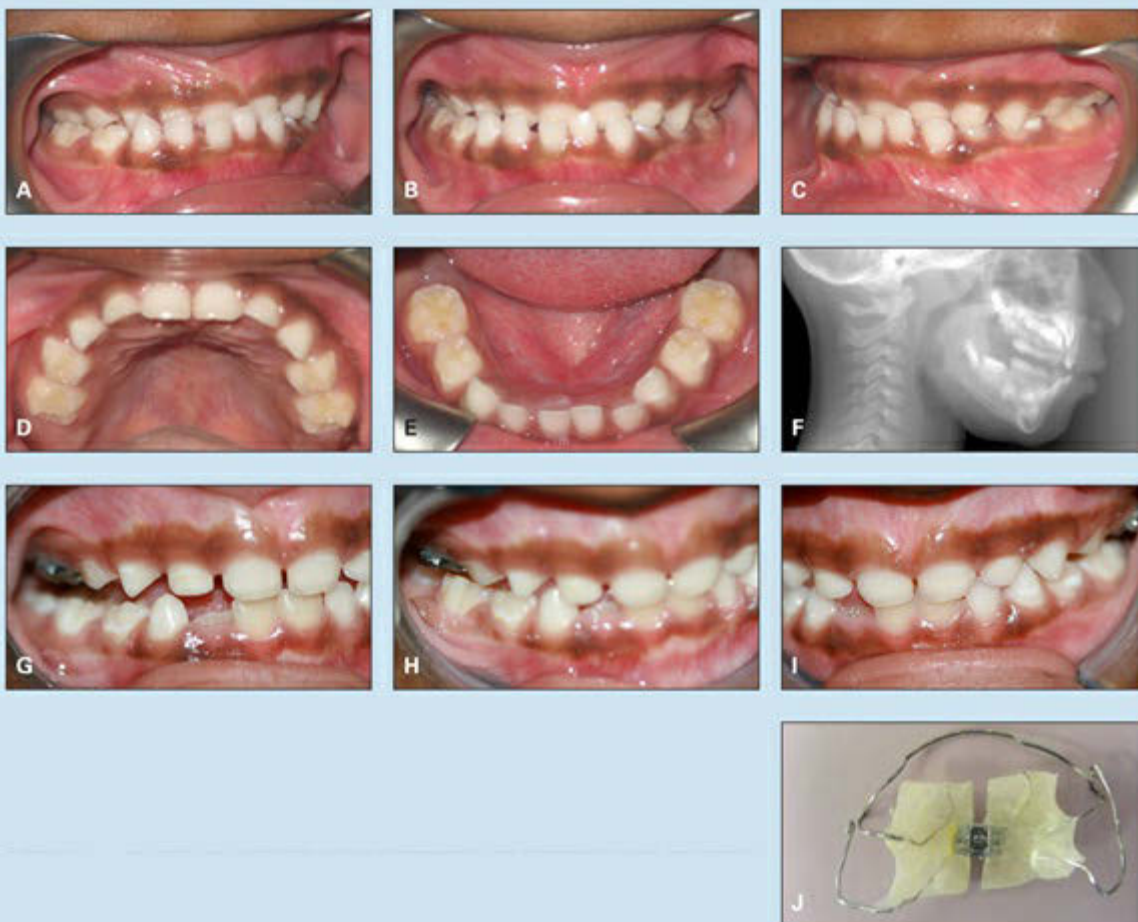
Management of complete unilateral and anterior crossbite and mandibular functional shift in a 5-year-old girl in the primary dentition. (*A to E*) Pretreatment occlusion. (*F*) Pretreatment cephalometric radiograph. (*G*) Occlusion after correction of anterior crossbite but before correction of posterior occlusion. (*H and I*) Occlusion after more occlusal contact has been established in the posterior segments. (*J*) Appliance used in treatment, after removal of occlusal coverage.
